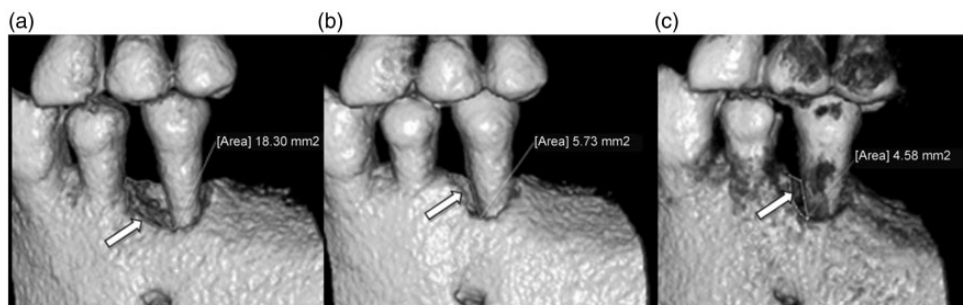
Cone beam volumetric tomography images of the left lower premolar area of a 61-year-old male patient with periodontal disease, showing: (a) boundary of the initial bone defect area of 18.30 mm² (arrow) at baseline; (b) bone defect area reduced to 5.73 mm² (arrow) at three months following dental pulp stem cell graft; and (c) bone defect area reduced to 4.58 mm² (arrow) at six months following dental pulp stem cell graft.
